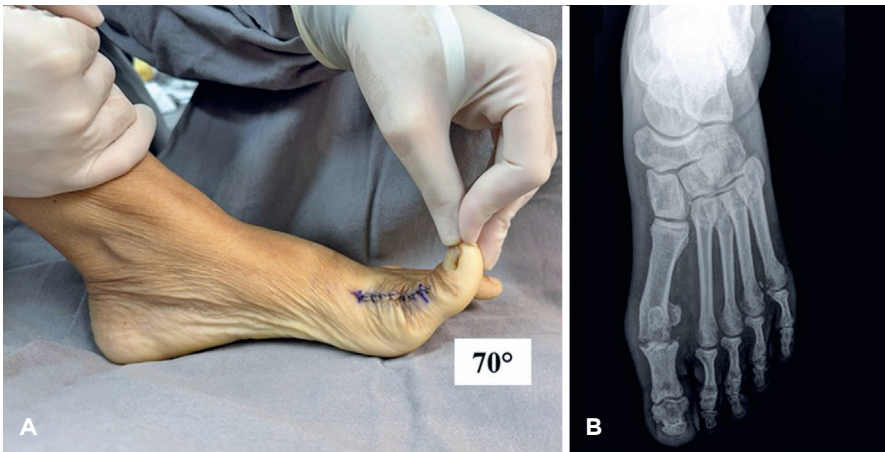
Assessment of range of motion and radiography after surgery at the time of the last follow-up. (A) Clinical assessment of the range of motion of the first joint. (B) Anteroposterior radiograph demonstrating bone resection level and preserved joint space. Observe the relatively equal lengths of the first and second metatarsals.
